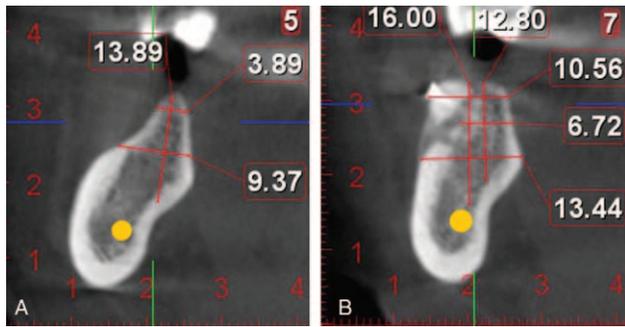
(A) Initial CT. (B) Control CT 4 month post-op. CT, computed tomography.
